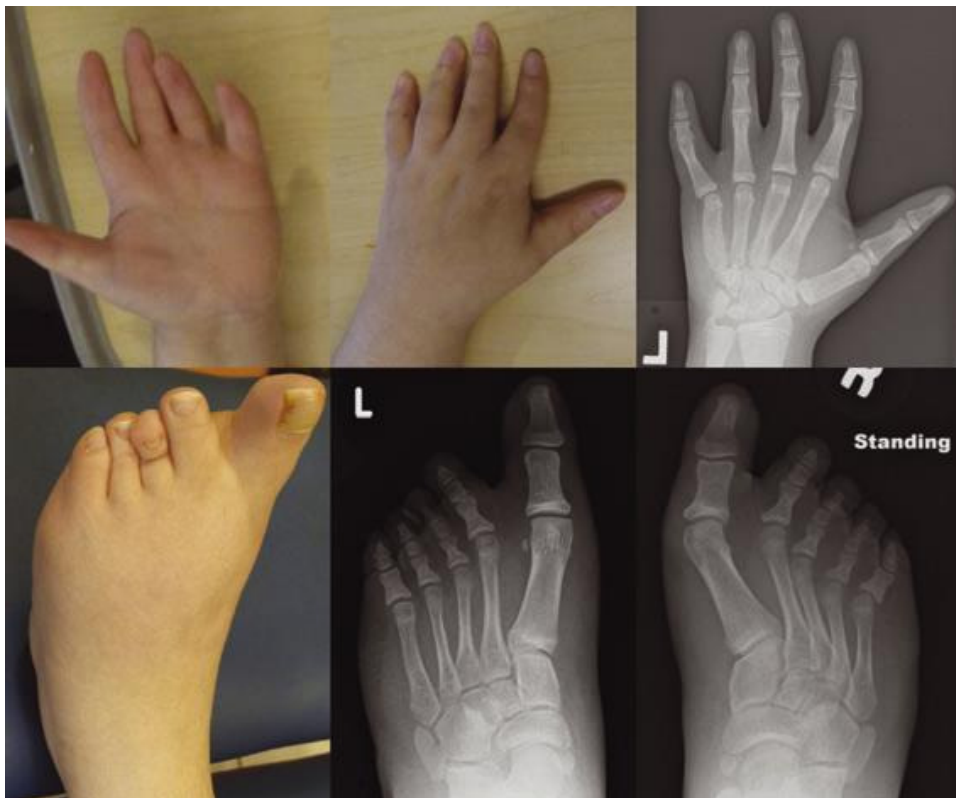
Upper and lower digits. Upper panel shows images of the dorsal and palmar surfaces as well as a radiographic image of the left hand. Left hand is notable for brachydactyly and clinodactyly, as well as some soft tissue syndactyly of the 2nd to 4th digits. Lower panel shows left dorsal foot and radiographic images of both feet. The patient has pes planus, widely spaced 1st and 2nd toes, and mild syndactyly of the 2nd and 3rd toes.
